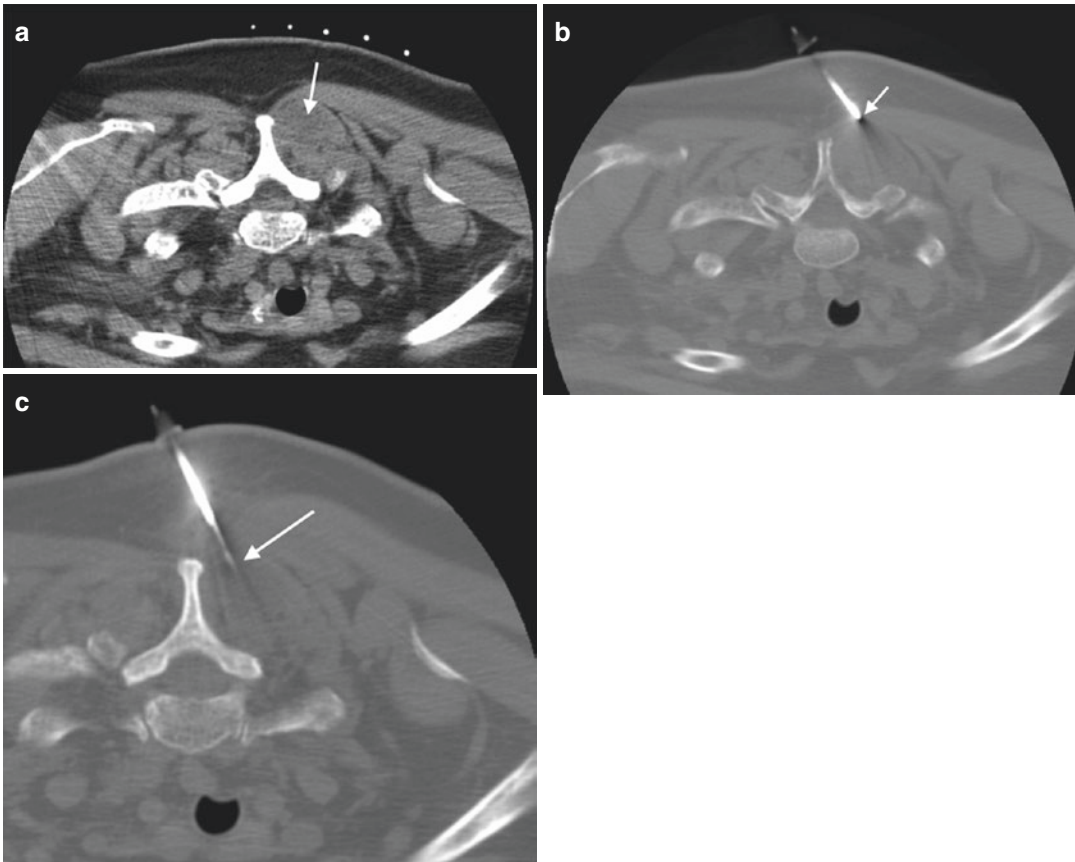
63F with palpable posterior neck mass. Axial CT image in soft tissue algorithm (a) shows skin markers placed above a slightly hypodense mass that is located beneath the trapezius muscle (*arrow*). Axial CT image in bone window algorithm (b) shows guide needle placement just superficial to the lesion (*arrow*). Note that the guide needle is obliquely
